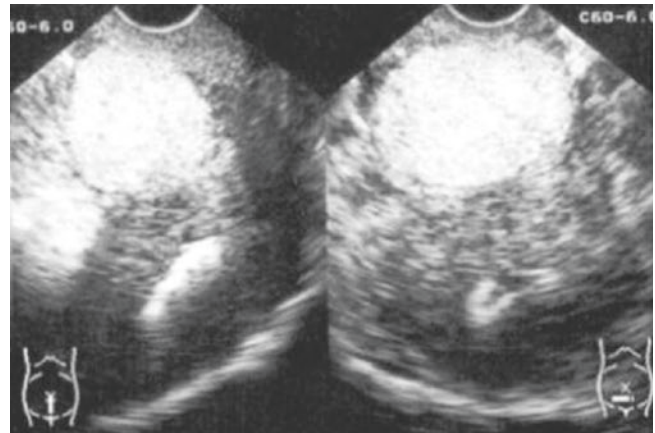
Myoma degeneration. The patient has a history of myoma for 8 years. Ultrasound shows that the diameter of the inhomogeneous myoma is more than 8.0 cm, and there are several liquid dark areas in the myoma. hCG is negative
